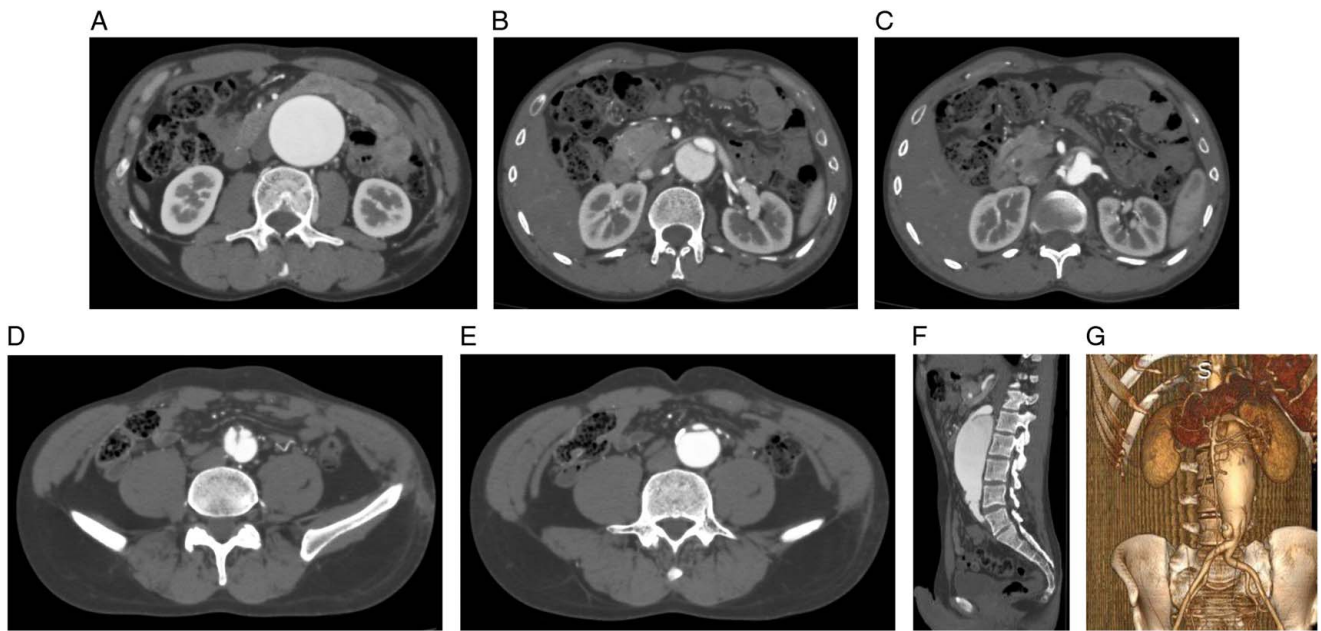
(A) Preoperative contrast-enhanced Multi-Slice Computed Tomography (MSCT) image of the abdomen and pelvis in axial view. It demonstrates the infrarenal abdominal aortic aneurysm measuring 5.5 cm whereby its outer surface appears extremely thin. (B, C) Preoperative contrast-enhanced MSCT image of the abdomen and pelvis in axial view. It reveals a dissection flap at the neck section of the aneurysm at the level of origin of the renal arteries. (D, E) Preoperative contrast-enhanced MSCT image of the abdomen and pelvis in axial view. It reveals a dissection flap at the end of the abdominal aorta prior to the origin of the iliac arteries. (F) Preoperative contrast-enhanced MSCT image of the abdomen and pelvis in sagittal view. It demonstrates both of the dissecting flaps mentioned in the previous figures and shows how the flaps are free as we have a true arterial lumen. (G) Preoperative contrast-enhanced MSCT image of the abdomen and pelvis in coronal view with three-dimensional reconstruction showing the infrarenal abdominal aortic aneurysm.
